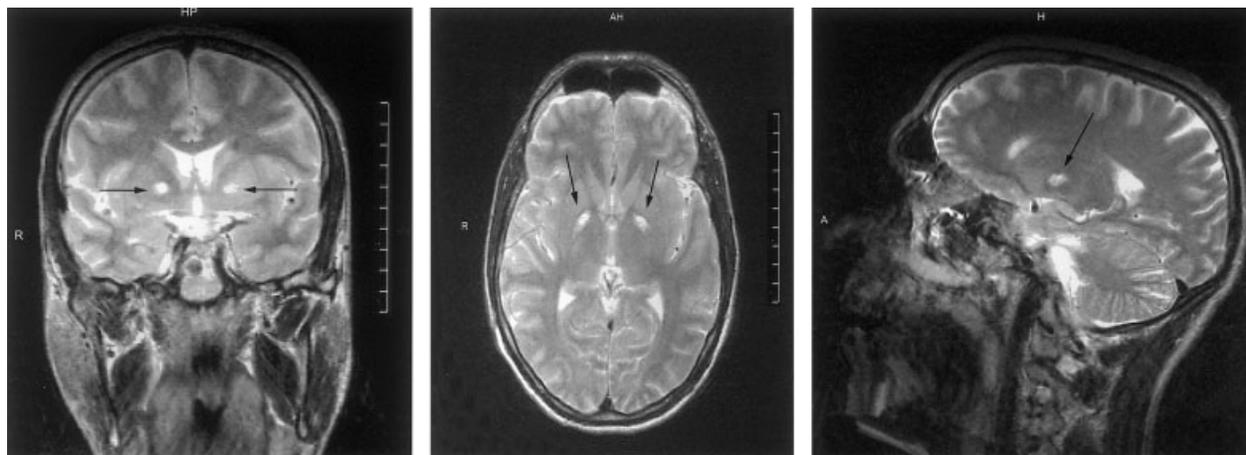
Magnetic resonance imaging scans showing bilateral pallidal signal change (arrows).
